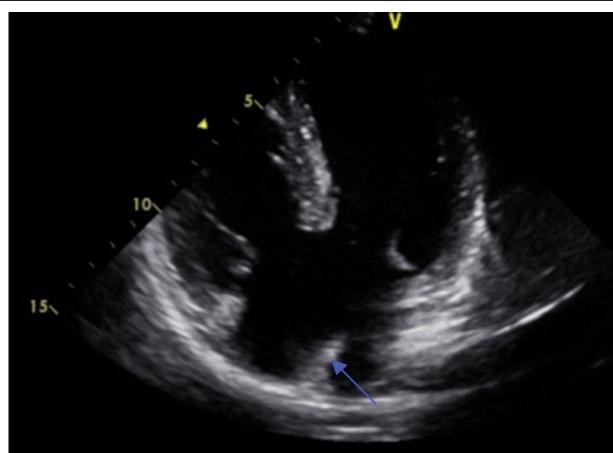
Echocardiography: complete atrioventricular septal defect, reduced vertex inter-ventricular communication, wide communication inter-atrial (arrow).
